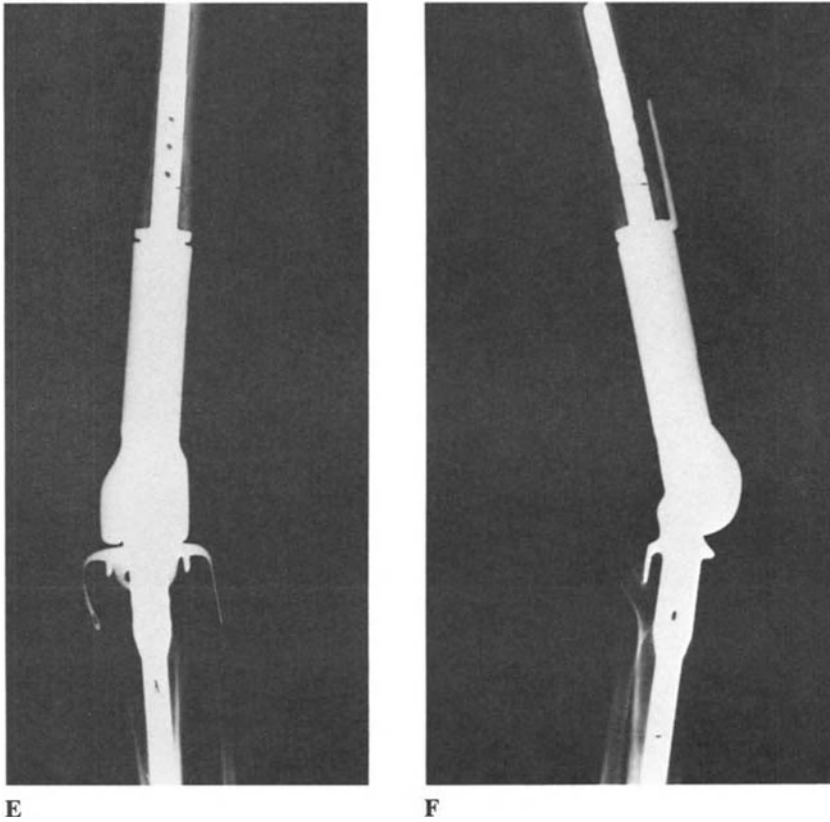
Osteoblastic osteosarcoma in a 24-year-old male. A, B: Standard x-rays of the distal femur. C: CT scan of the lesion. D: MRI on a coronal view, showing the longitudinal extension of the tumor; E, F: Wide resection and reconstruction with K.M.F.T.R. prosthesis.
